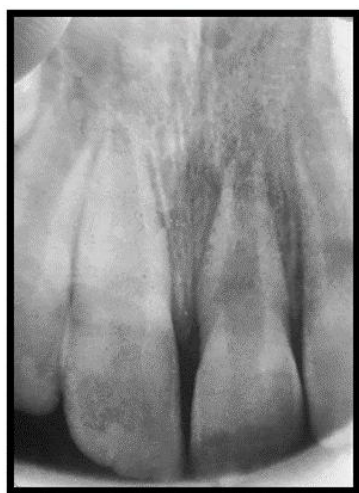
The initial periapical X-ray showing immature central incisor with the open apex and a radiolucent area in the apical region
